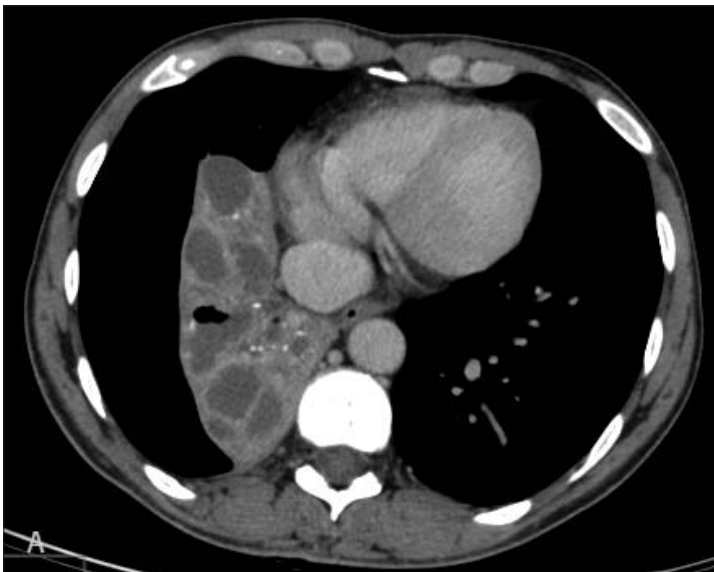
CT scan with contrast medium: on the right atelectasis of middle and lower lobes with multiple, gross, cyst-like bronchiectasis.
